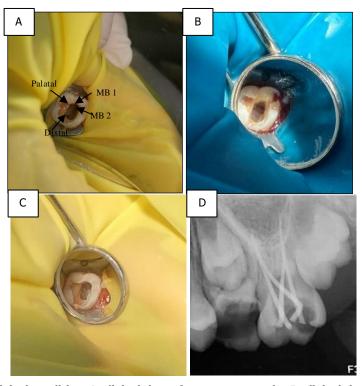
Clinical condition; A. clinical view of access preparation B. clinical view of 3 month during treatment, C. clinical view of 6 month during treatment, D. radiograph view of gutta perchatrial.
